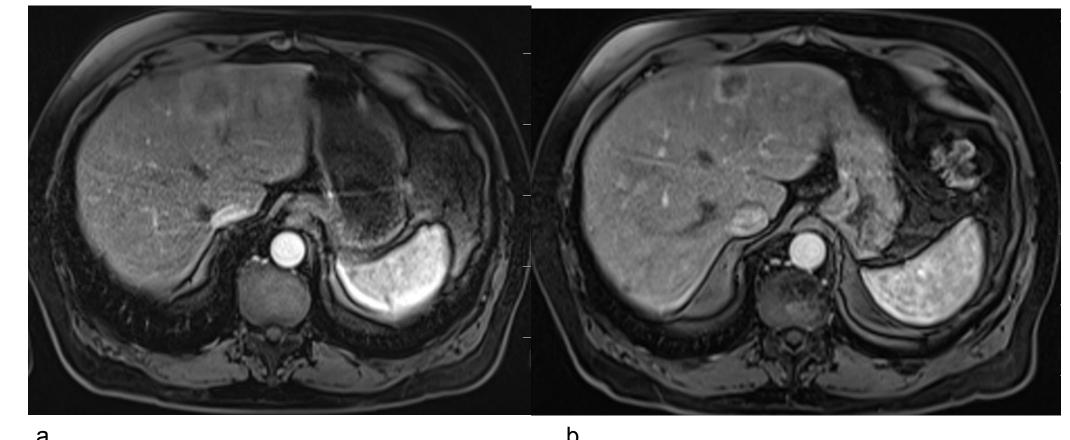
Magnetic resonance images (T1) of the first patient with diffuse liver metastases from uveal melanoma;
